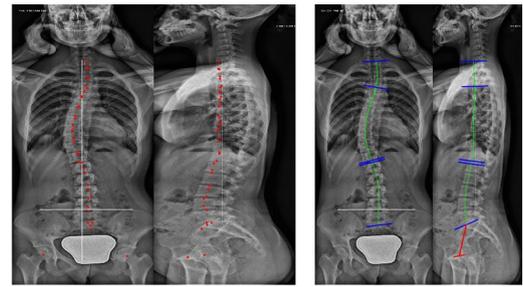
Representative scaled biplanar radiographs showing the 78 landmarks, which included the center of the upper (red) and lower (blue) end plates of the thoracolumbar spine, the center of the hip joints (green), and the anterior and posterior margins of the S1 end plate (yellow)
